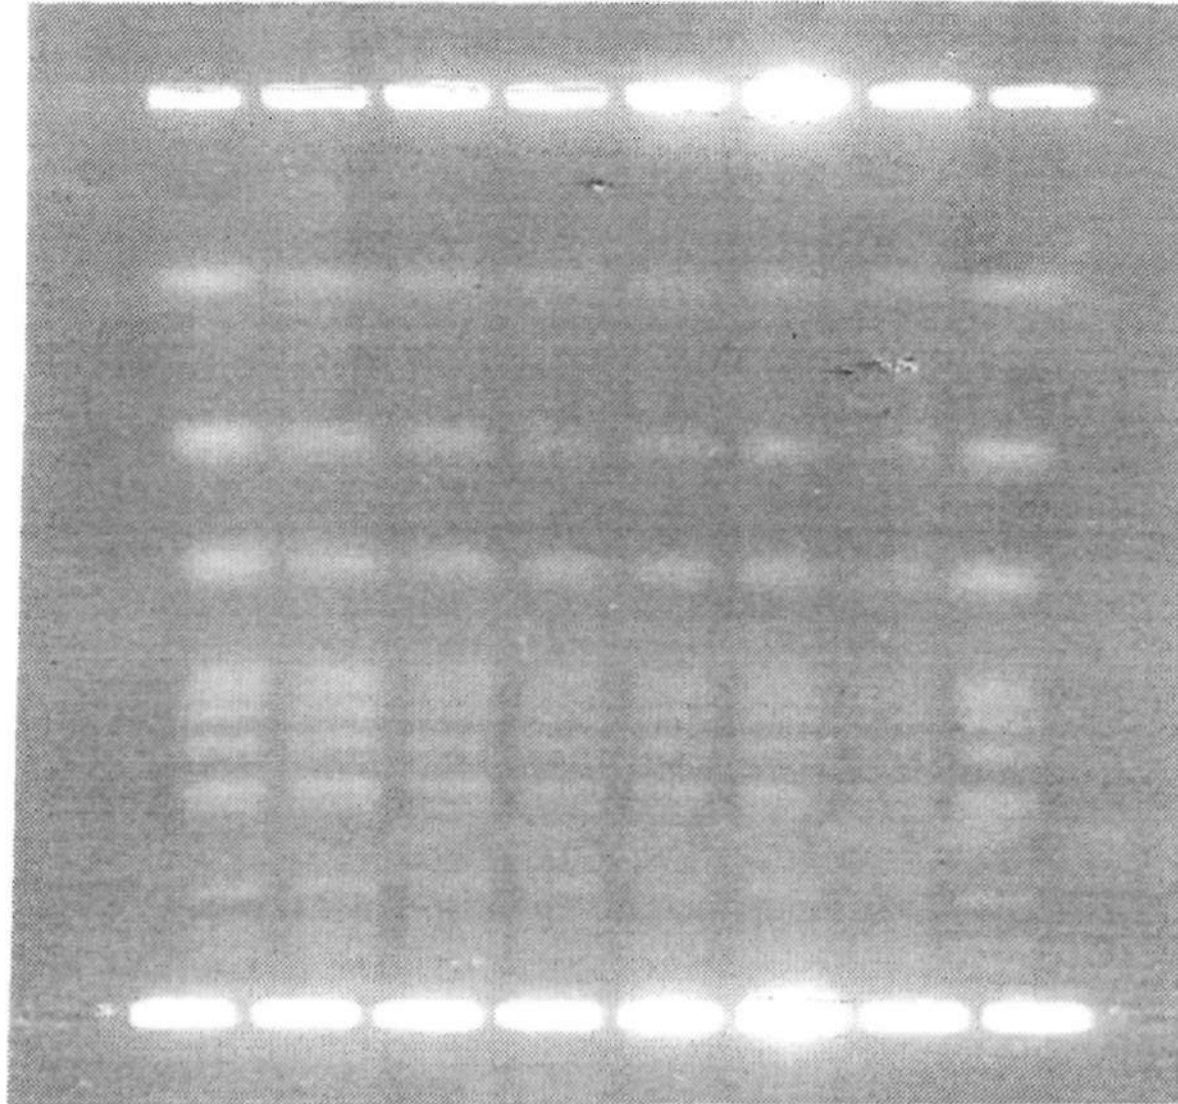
An uncorrected gel picture of unirradiated (lanes 1 and 9) and irradiated (lanes 3-8, with X-ray doses of 41, 82, 164, 246, 328 and 410 Gy, respectively) rad 54-3 mutant of yeast *S. cerevisiae* after electrophoresis.
